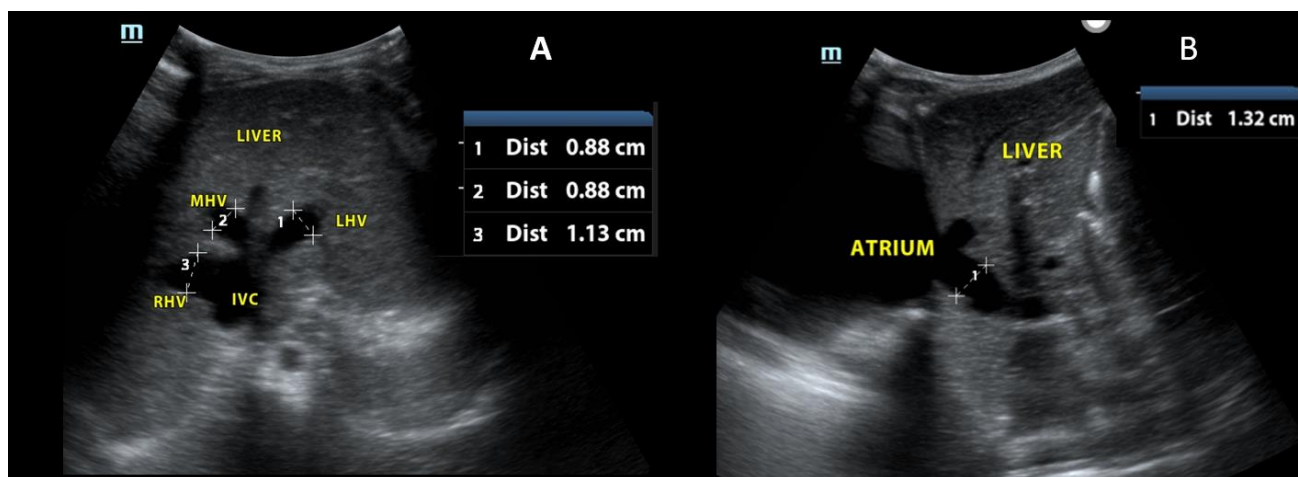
2D sonogram transverse view of the liver through the confluence of the hepatic veins to the inferior vena cava(A), The hepatic veins are dilated, LHV-8.8mm, MHV-8.8mm, RHV-11.3mm. sagittal view of the liver demonstrating the IVC and its diameter-13.2mm], LVH-left hepatic veins, RHV-right hepatic vein, MHV-middle hepatic vein
